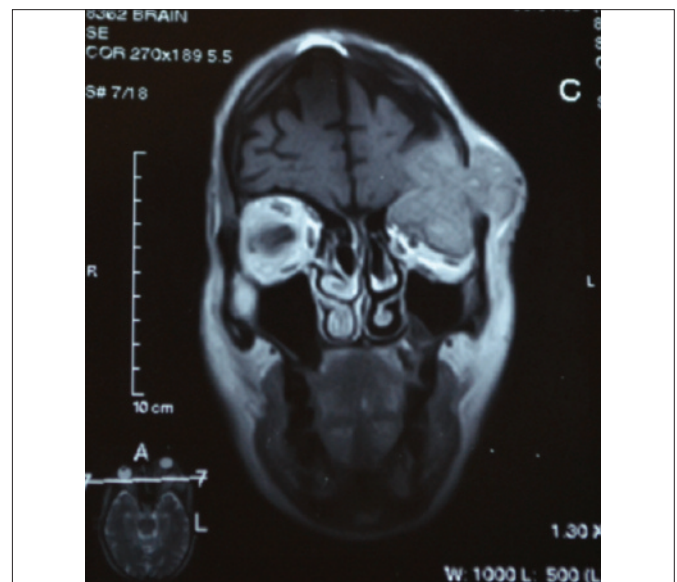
MRI brain and orbit: A large soft tissue mass in the left frontal region involving the skull vault and extraclavial region with intracranial extension. The mass was occupying the left side of the orbit abducting the eyeball.
